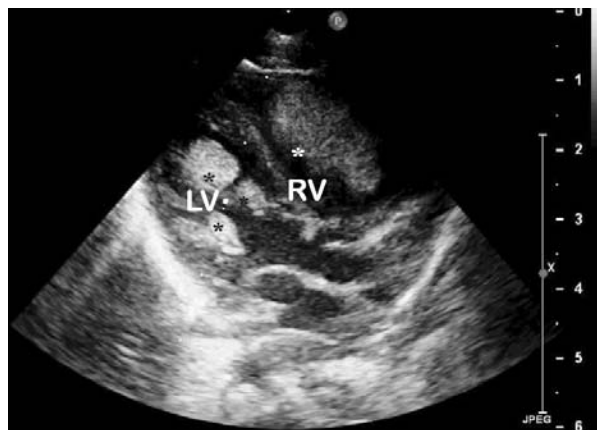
Echocardiogram (parasternal long-axis view) showing multiple cardiac masses in left ventricle (LV) and right ventricle (RV).
